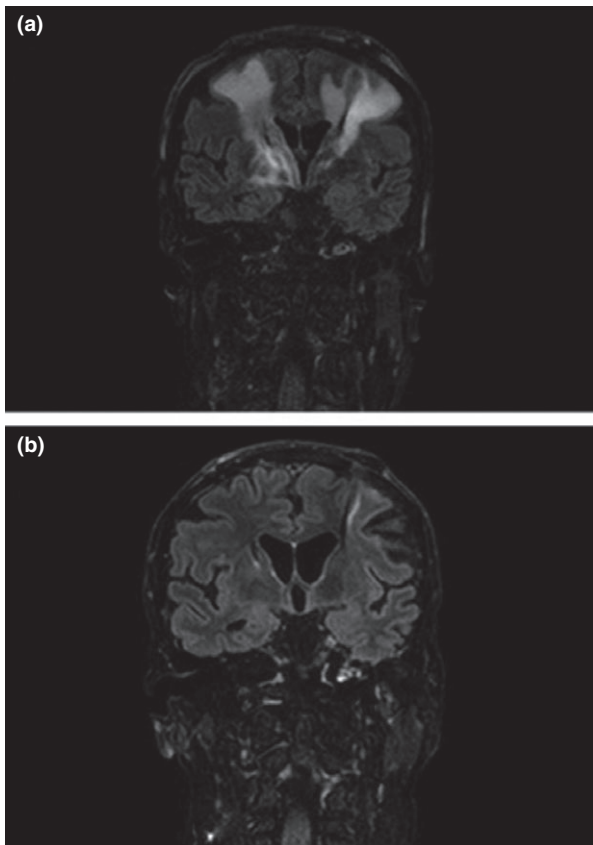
Fluid-attenuated inversion recovery coronal sections showing the spontaneous evolution of peri-lead edema. (a) Conspicuous peripheral and deep edema in early post-operative magnetic resonance imaging (MRI) (patient 1, post-operative day 8). (b) Complete resolution of edema in mid-term follow-up MRI (patient 1, post-operative day 47). This section reveals small artifacts along both leads.
